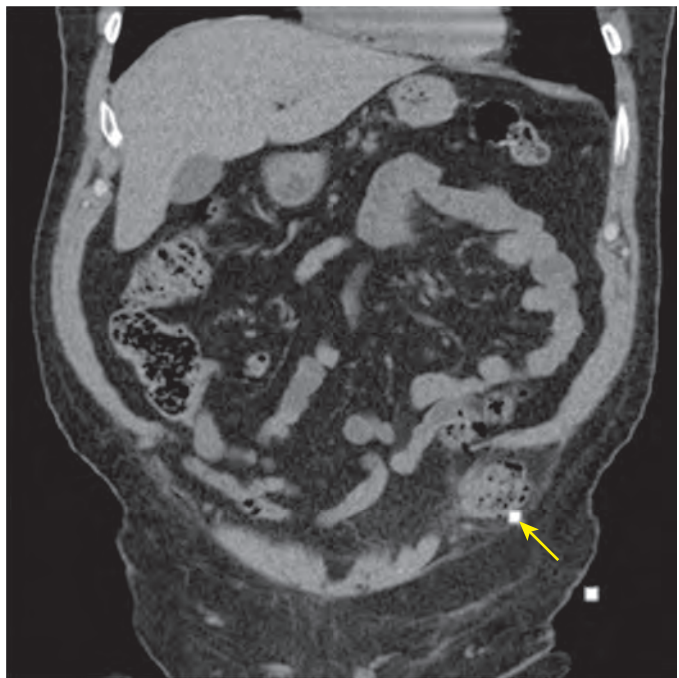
Spigelian hernia. CT shows herniated small bowel through a peritoneal defect at the lateral border of the left rectus muscle (arrow), which was a prior laparoscopic port site.
